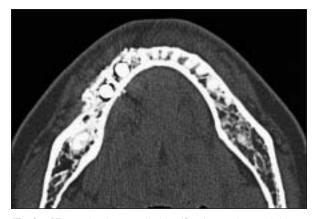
CT examination revealed ossification at the mesial margin of the osteotomy.
